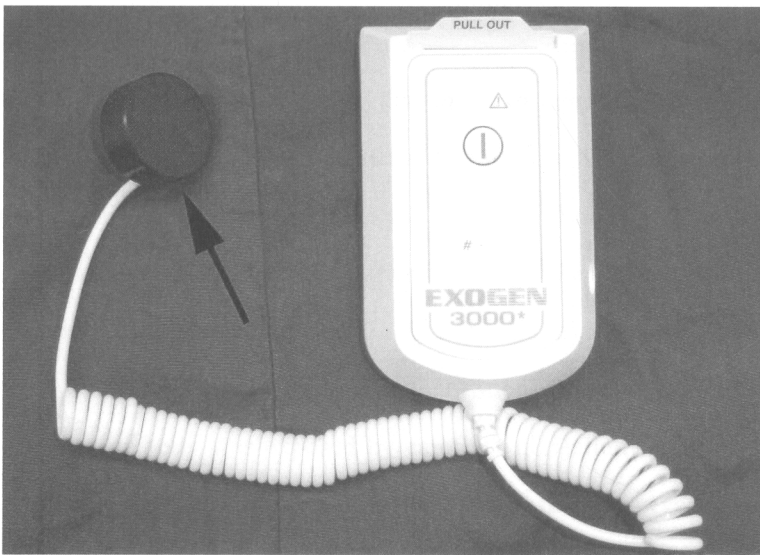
Low intensity pulsed ultrasound device.
